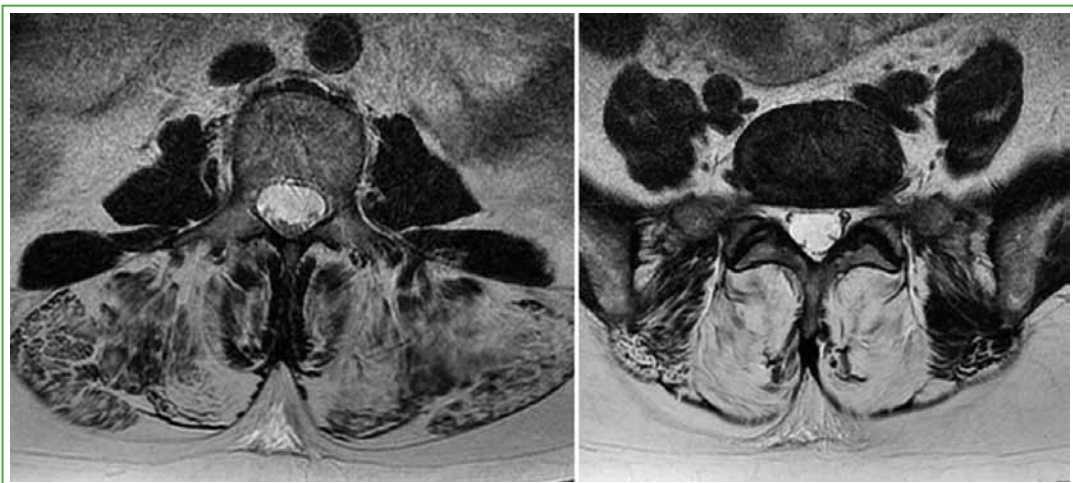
MRI transverse section of T2 of a 60-year-old woman with type 2 Diabetes history who presented progressive weakness to maintain an up-straight position. At L3 and L5 the scan shows a massive fatty replacement of the erector muscles with no volume decrease of the muscle compartment.
